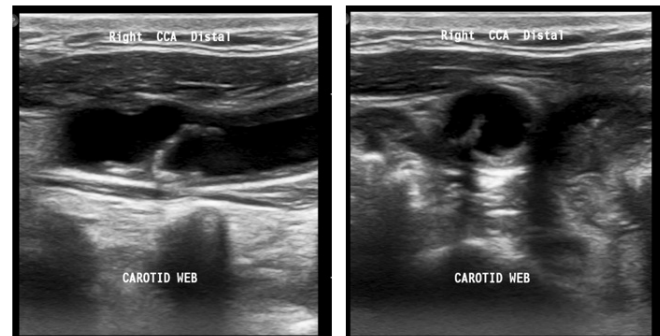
Longitudinal (left) and transverse (right) distal common carotid ultrasound showing a shelf-like intraluminal projection at the posterior wall of the carotid bulb (arrow), consistent with carotid web.
